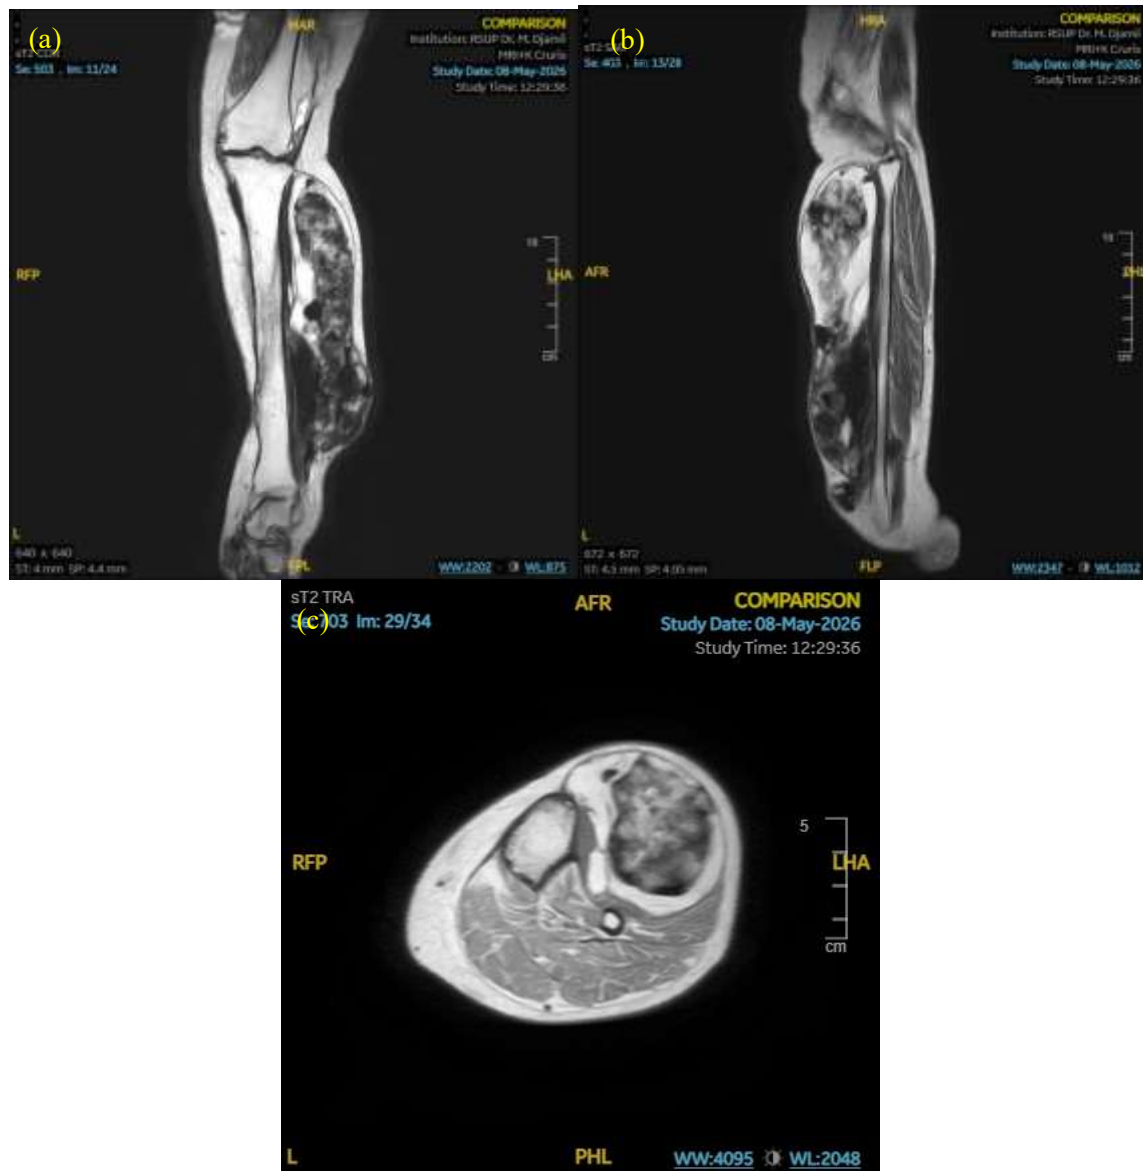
Coronal (a), sagittal (b), and axial (c) magnetic resonance images showing a large multicompartmental extraosseous lesion surrounding the fibula, with mineralized foci and no medullary replacement.
